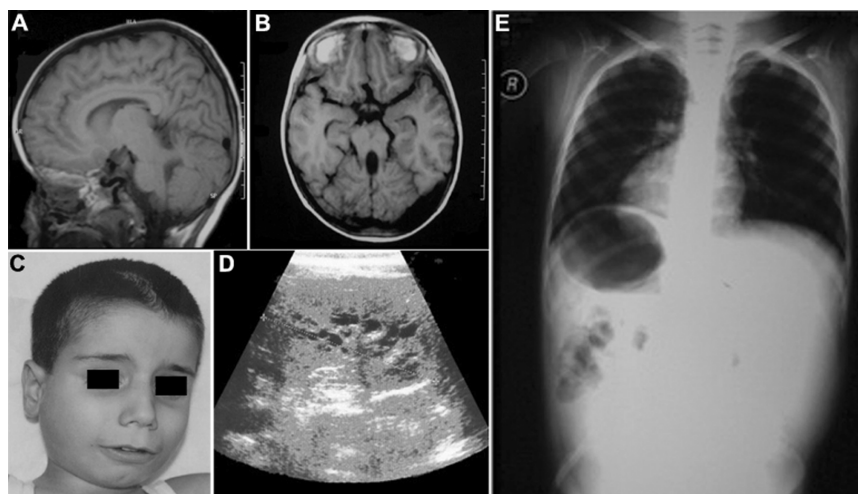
Patient MTI273, homozygous for the S1595fsX1599 mutation in exon 36 of the *CEP290* gene and presenting with JSRD-SLS associated with complete *situs inversus*. Sagittal (A) and axial (B) brain magnetic resonance imaging sections show the MTS malformation. C, Face showing absence of specific dysmorphic features. D, Kidney ultrasound displaying multiple renal cysts and increased echogenicity. E, Chest x-ray showing complete *situs inversus*, with stomach bubble and heart apex on the patient's right side (R).
